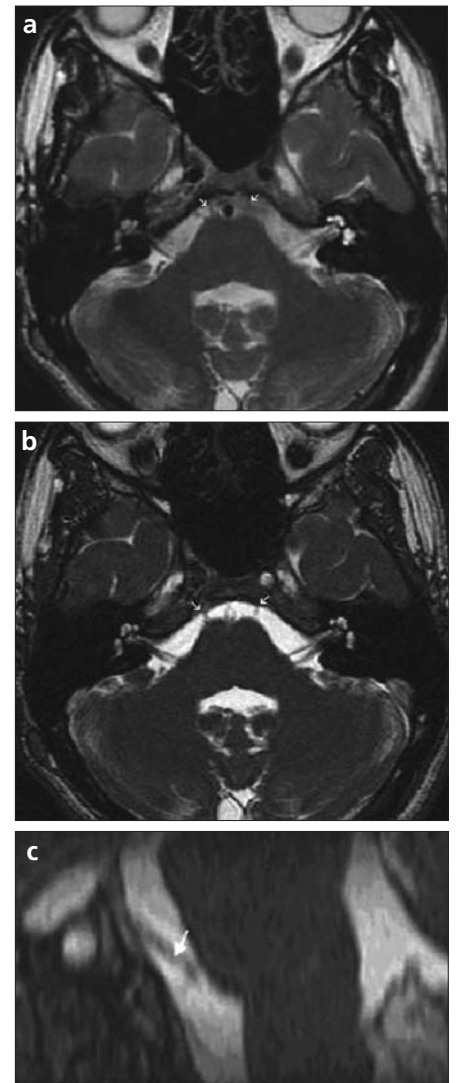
a–c. Cranial nerve VI. In axial FSE T2W MR image (a) nerve VI can be roughly visualized (arrows). In axial 3D FIESTA MR image (b) and sagittal MIP reconstruction MR image (c), it can be visualized clearly (arrows in b and c).
